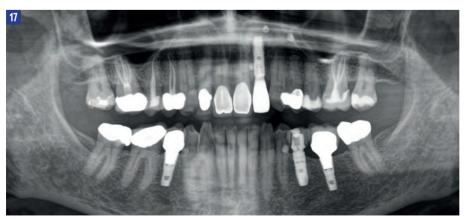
Five-year postoperative radiograph
